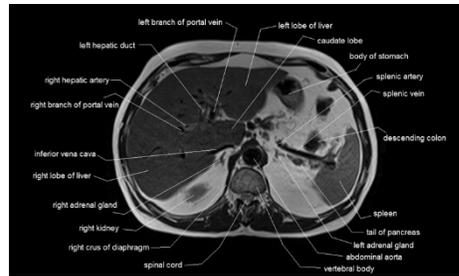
Cross-section of a human abdomen. Left side of this image is the hemisphere of focus. (MRI Abdomen Axial Cross Section)
